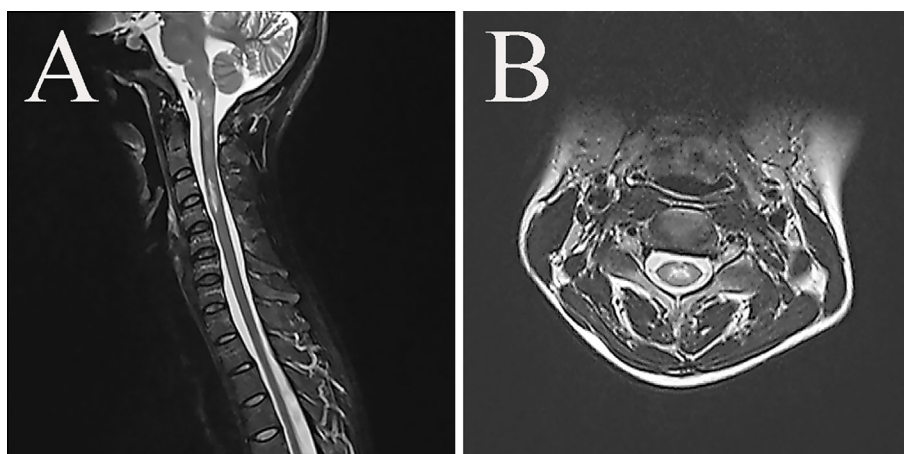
Spinal cord MRI in sagittal (A) and axial (B) T2-weighted images show lesions in cervical spinal cord with hyperintense signal, especially in the central gray matter. MRI: magnetic resonance imaging
